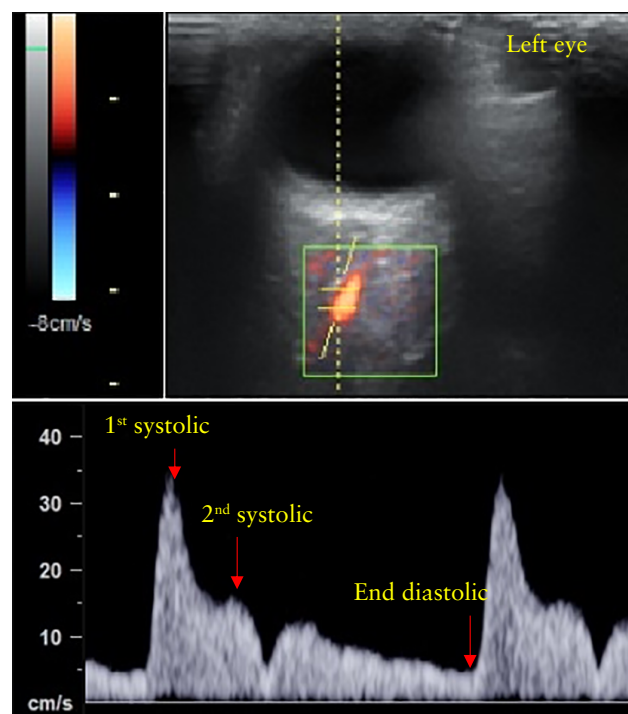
Ultrasound image of left orbit with color flow demonstration of left ophthalmic artery. At the bottom is flow velocity waveform from ophthalmic artery obtained by pulsed-wave Doppler, showing first and second peaks of systolic velocity and end-diastolic velocity.
